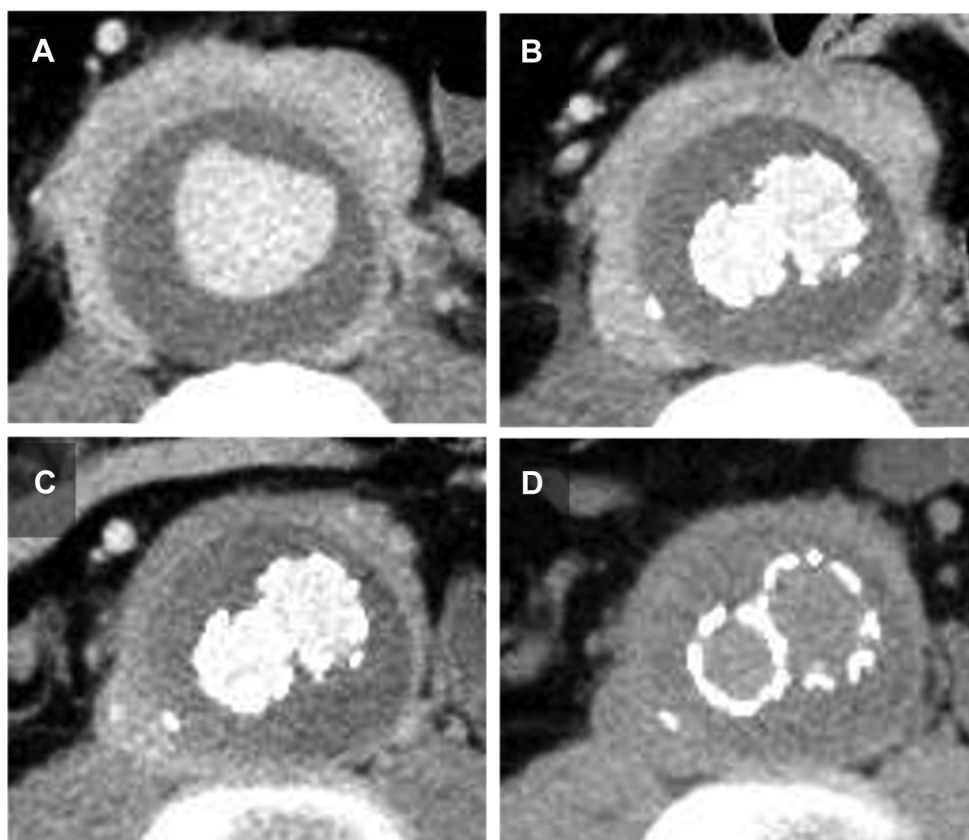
Follow-up computed tomography (CT) of aorta. A, Preoperative CT scan. B, One week after endovascular aneurysm repair (EVAR). C, Three months after EVAR. D, Six months after EVAR. The thickness of aortic adventitia gradually reduced.
